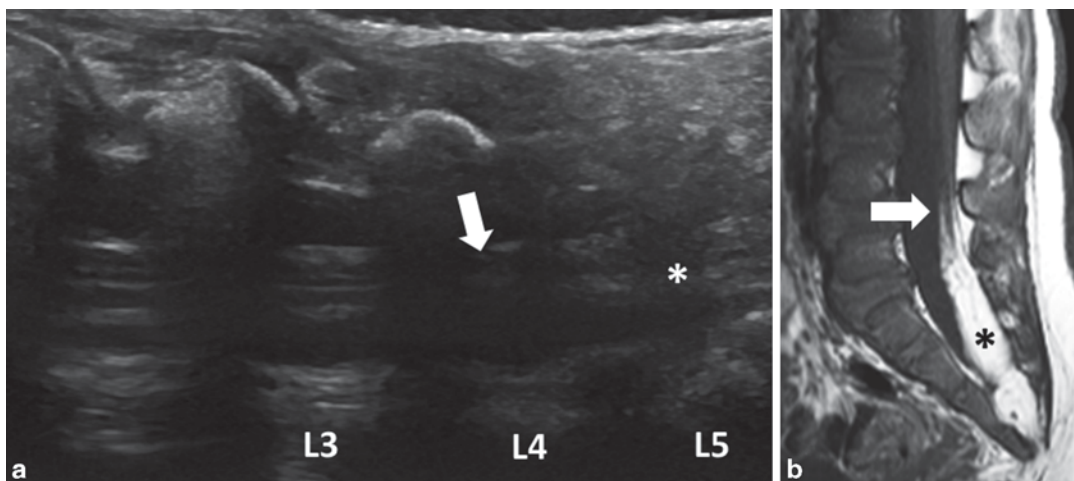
Terminal lipoma. Sagittal ultrasound images of the lumbosacral junction (a) and the sagittal MRI T1 weighted image (b). Tethered cord terminating at the level
